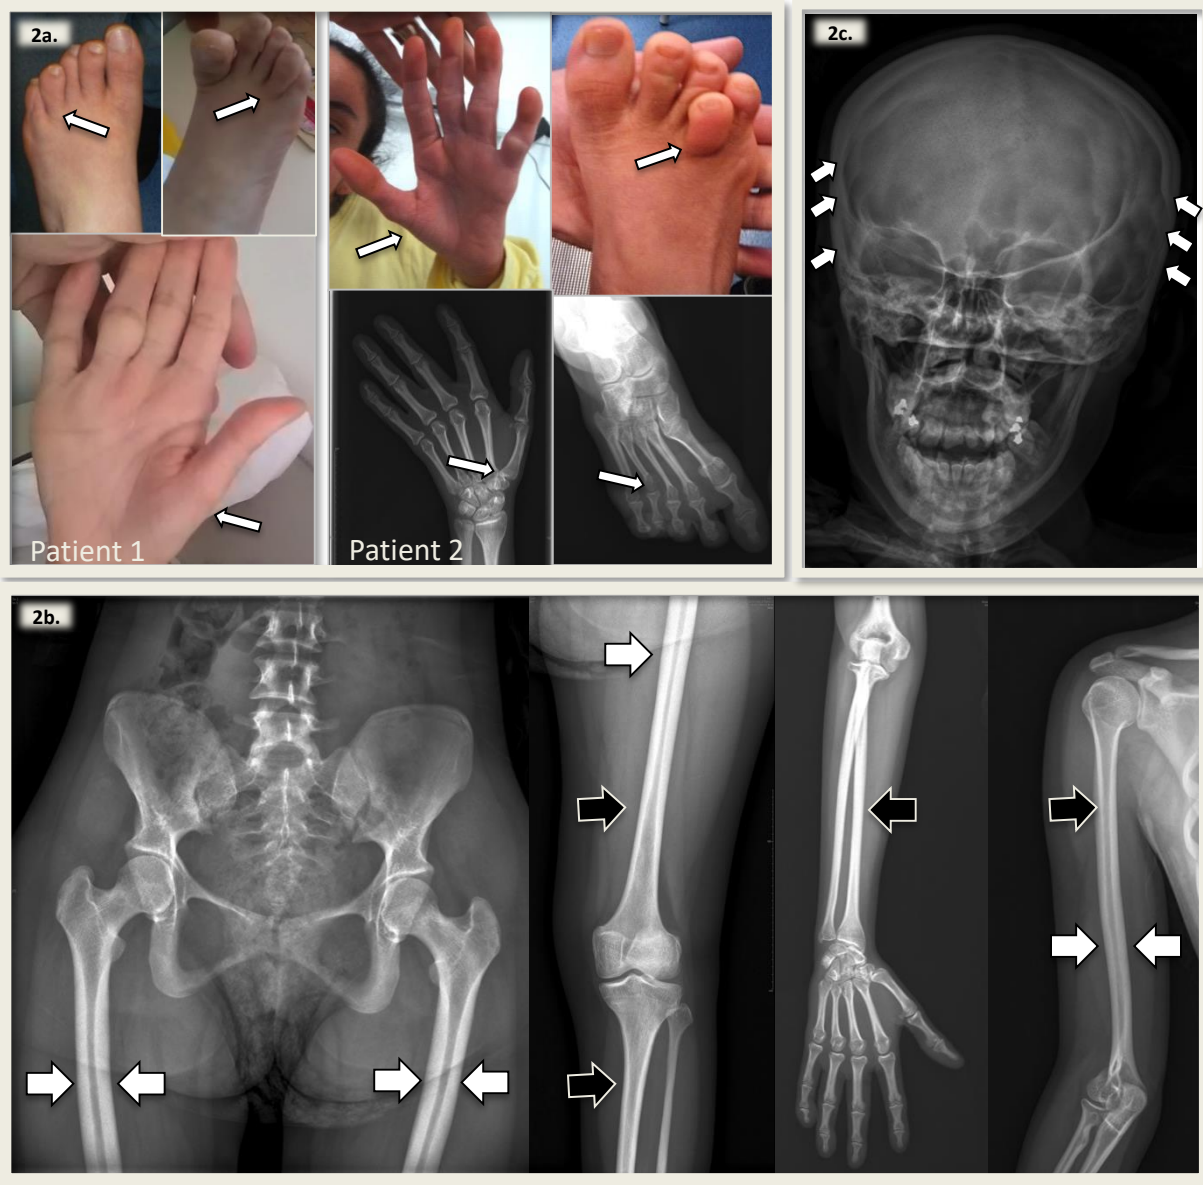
Skeletal features and X-rays views.
